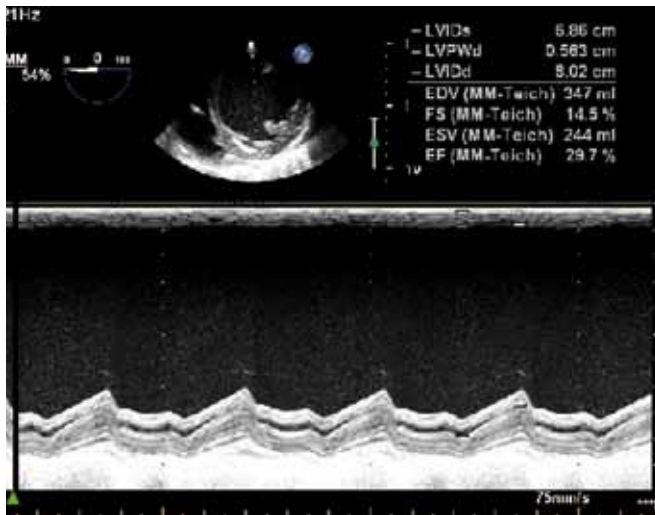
Inferior wall akinesia (Transgastric mid short axis view). Doppler has been applied across the left ventricle. Normal thickening and movement of the anterior wall can be seen during systole. In contrast, the inferior wall is akinetic. EF, ejection fraction; FS, fractional shortening; LVIDs, left ventricular internal diameter in systole; LVIDd, left ventricular internal diameter in diastole.
